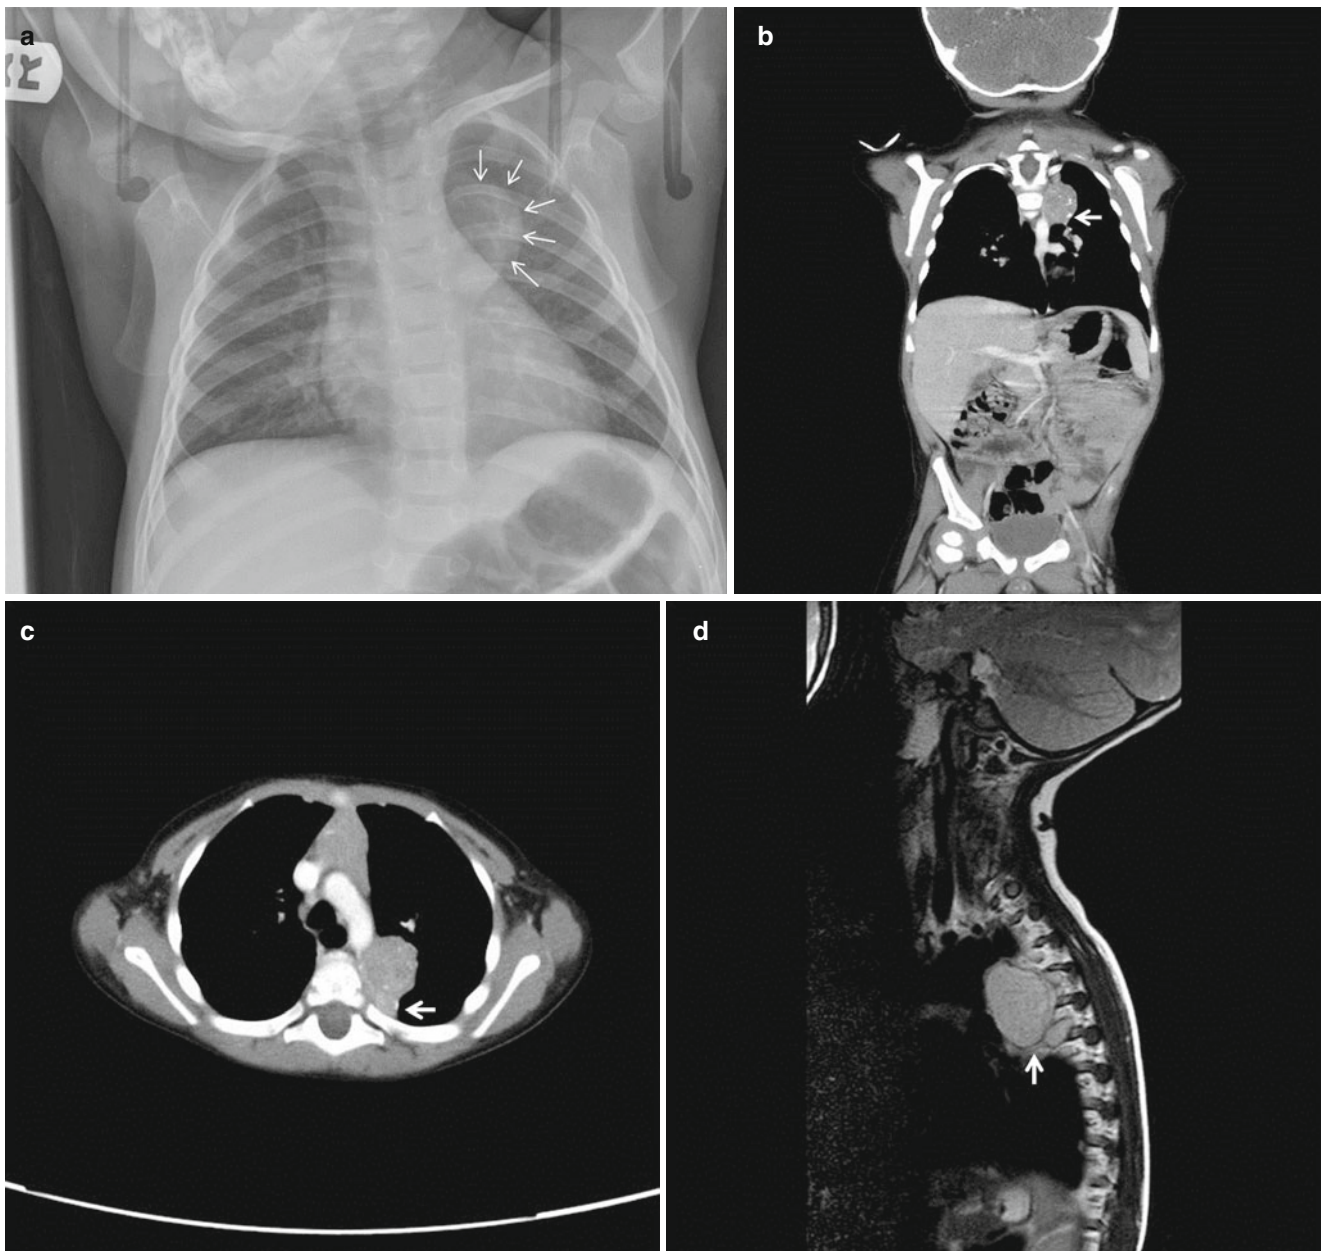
(a) A 17 month old boy presented with opsoclonus myoclonus. A brain MRI was negative and a chest radiograph obtained for suspected pneumonia showed a left paravertebral lesion (*arrows*), CT (b, c) and MRI (d) showed a lesion sitting adjacent to but not extending into the spinal canal (*arrow*). The tumor was resected thoracoscopically with concomitant excision of adjacent lymphadenopathy.
